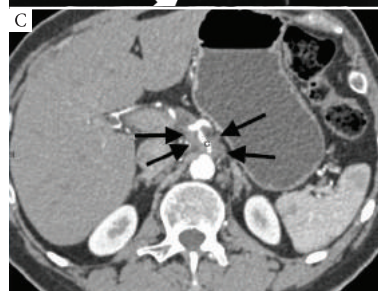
Transverse arterial-phase contrast-enhanced CT scan showing the coeliac artery (C) encased in tumour (arrows) that has spread by contiguous extension from a pancreatic neoplasm (not shown here).
